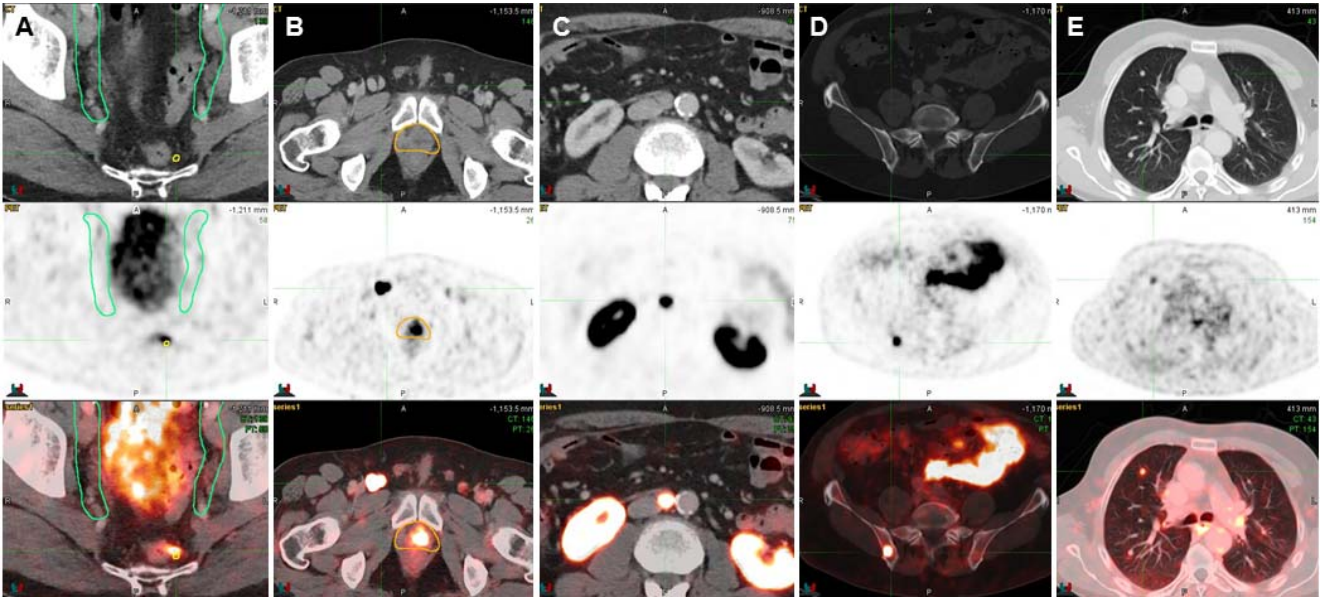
Examples of PSMA-positive lesions which are localized outside of consensus CTV from left to right: perirectal LN (A), inguinal LN (B), lumbo-aortic LN (C), bone (D), lung (E).
